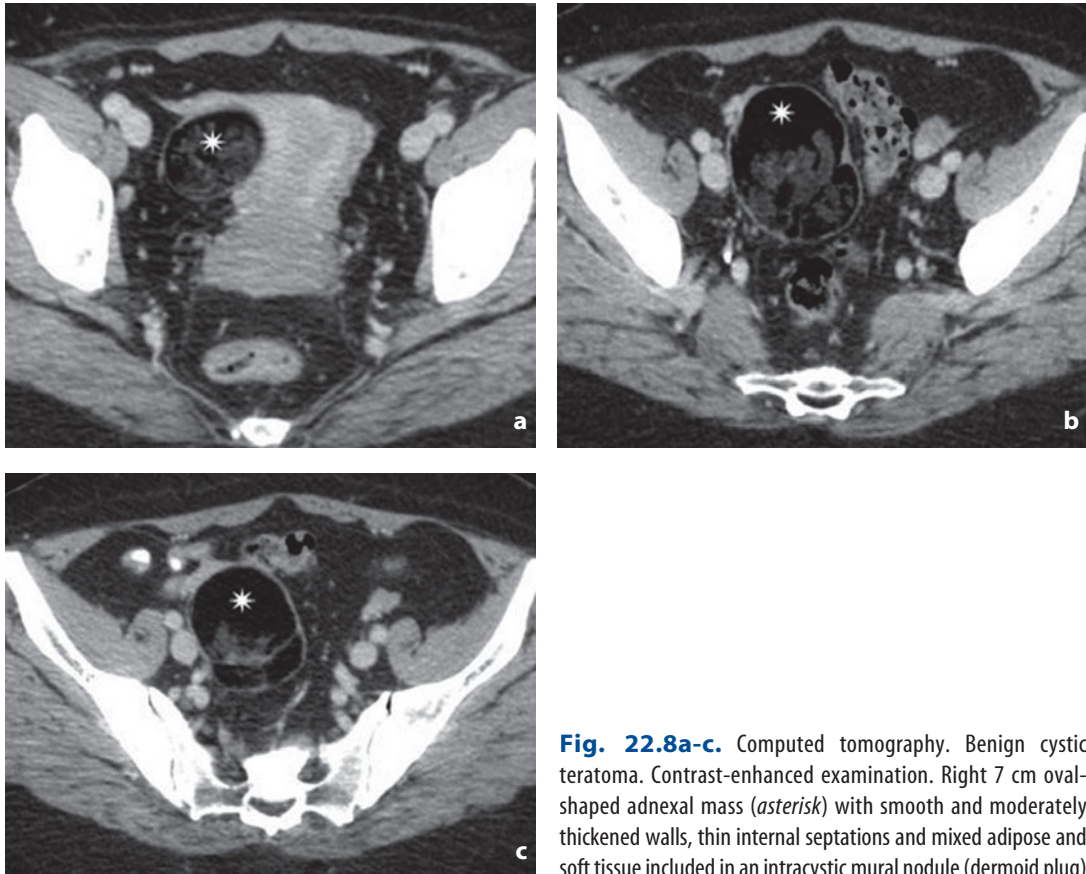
Computed tomography. Benign cystic teratoma. Contrast-enhanced examination. Right 7 cm oval-shaped adnexal mass (*asterisk*) with smooth and moderately thickened walls, thin internal septations and mixed adipose and soft tissue included in an intracystic mural nodule (dermoid plug)
